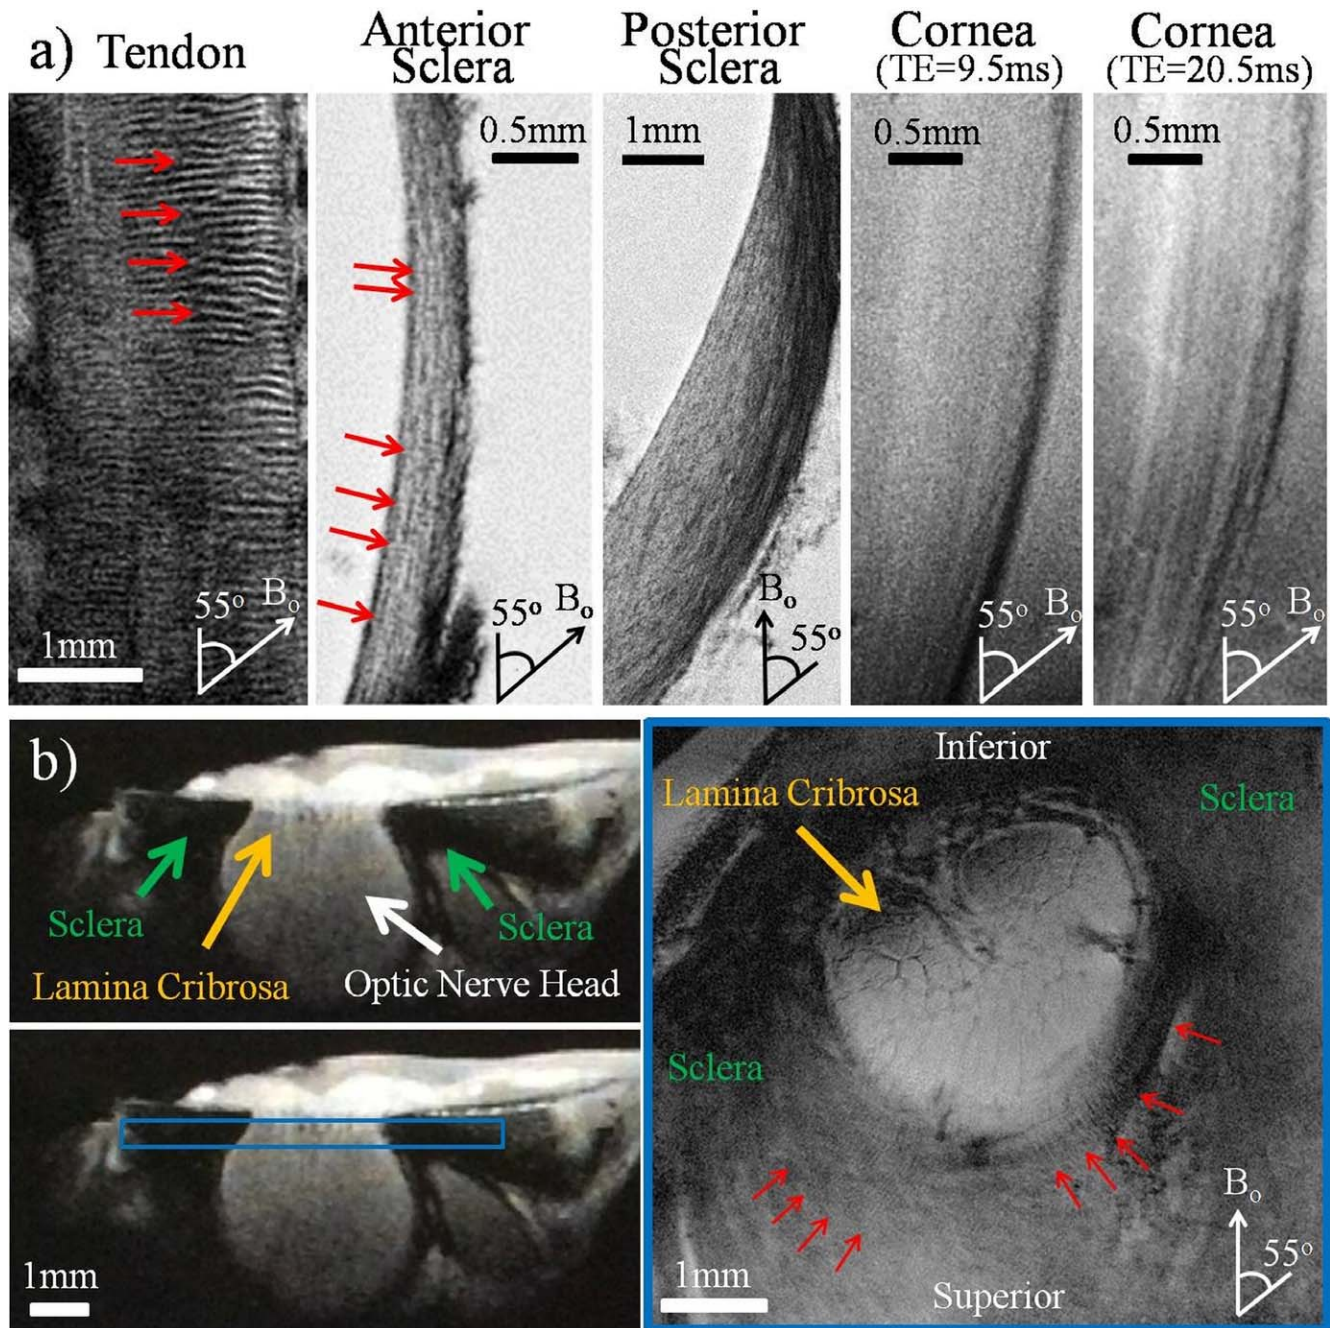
(a) High-resolution T2*-weighted MR images of the normal unloaded tendon, anterior sclera, posterior sclera, and cornea positioned at the magic angle at approximately 55° to the main magnetic field (B_0). Collagen fiber crimps (red arrows) were observed in the tendon positive control and the anterior sclera. Lamellar fibers were observed along the anterior and posterior sclera, whereas differential image contrasts were found across corneal layers at echo times of 9.5 and 20.5 ms. Outer layers are to the right in the sclera and cornea images. Repetition time for all tissues = 3 s; echo time of tendon, anterior sclera, and posterior sclera = 8, 9.5, and 8 ms, respectively; in-plane resolution of tendon, anterior sclera, posterior sclera, and cornea = 20 × 20, 16 × 16, 20 × 20, and 16 × 16 μm^2 , respectively. (b) T2*-weighted MR images of the unloaded sclera near the optic nerve head. The left panels show the cross-section of the sclera, optic nerve head, and lamina cribrosa in sagittal view. The right panel shows the coronal T2*-weighted image oriented as the blue box in the left panel at 16 × 16 μm^2 in-plane resolution and repetition time/echo time = 3000/9.5 ms. Details of the lamina cribrosa (yellow arrow) within the optic nerve head and the distributions of crimps (red arrows) in the scleral fibers surrounding the optic nerve head were revealed especially at orientations near the magic angle.
